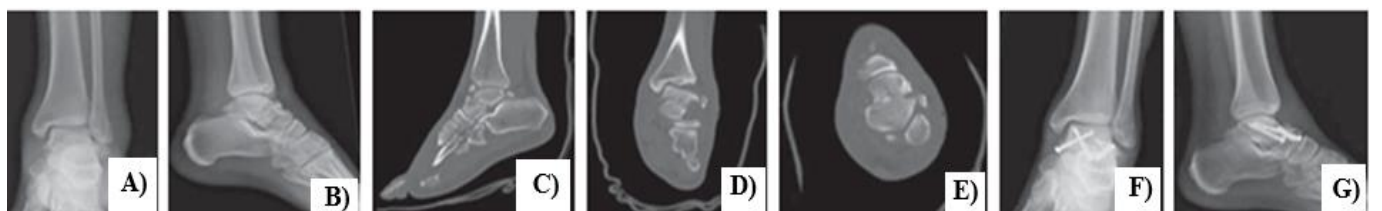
A 24-year-old man sustained a Hawkins type II talar neck fracture while riding his bicycle with a fixed cleat pedal (A, B). CT scans show the comminuted fracture of the talus, which extends through the neck to the middle articular facet (C,D,E). Radiographs 7 months after open reduction and internal fixation. Dual approaches were used, and that fracture fixed with 2 AP screws and a 2-mm lateral plate to maintain the talar neck length (F, G).
